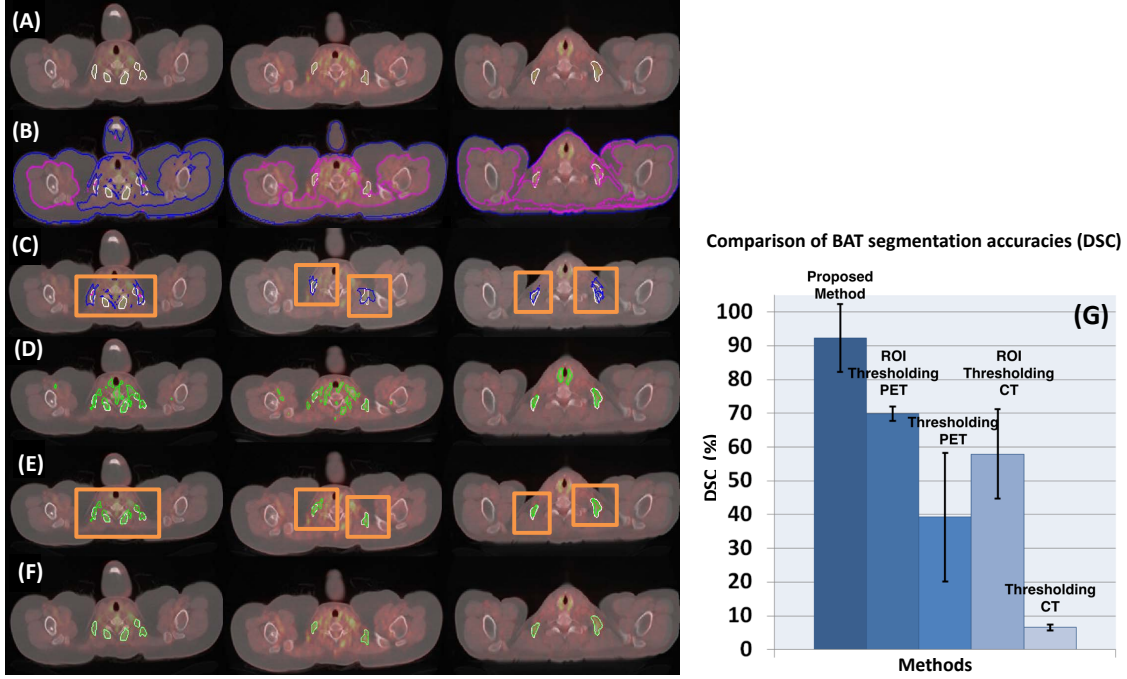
For three different anatomical levels (columns), row (A) shows reference standards (white); row (B) demonstrates the results from CT thresholding where pink (inner) and blue (outer) contours show brown fat delineation (blue contour shows fat region near skin boundary which leaks into the body cavity and also overlaps with pink contour as in the first column); row (C) comprises the results from ROI (Region of Interest) based CT thresholding, where orange boxes show user drawn ROIs and blue contours are the brown fat delineation results; row (D) shows the results from conventional PET thresholding, where green contours show output BAT delineations; row (E) depicts the ROI based PET thresholding; and row (F) demonstrates the proposed algorithm's delineation results using PET and CT jointly. (G) Dice Similarity Coefficients (DSC) of the proposed method in comparison with ROI based PET thresholding, PET thresholding, ROI based CT thresholding, and CT thresholding methods are shown.
